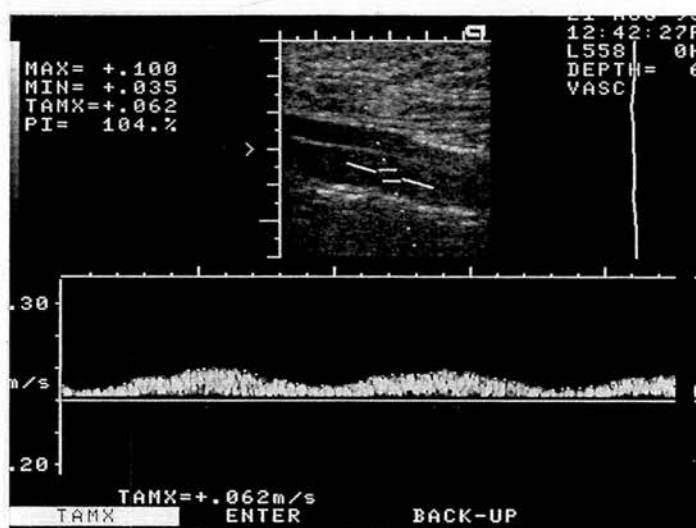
The spectral representation of the Doppler waveform is traced over 15 seconds and the TAMV calculated.
